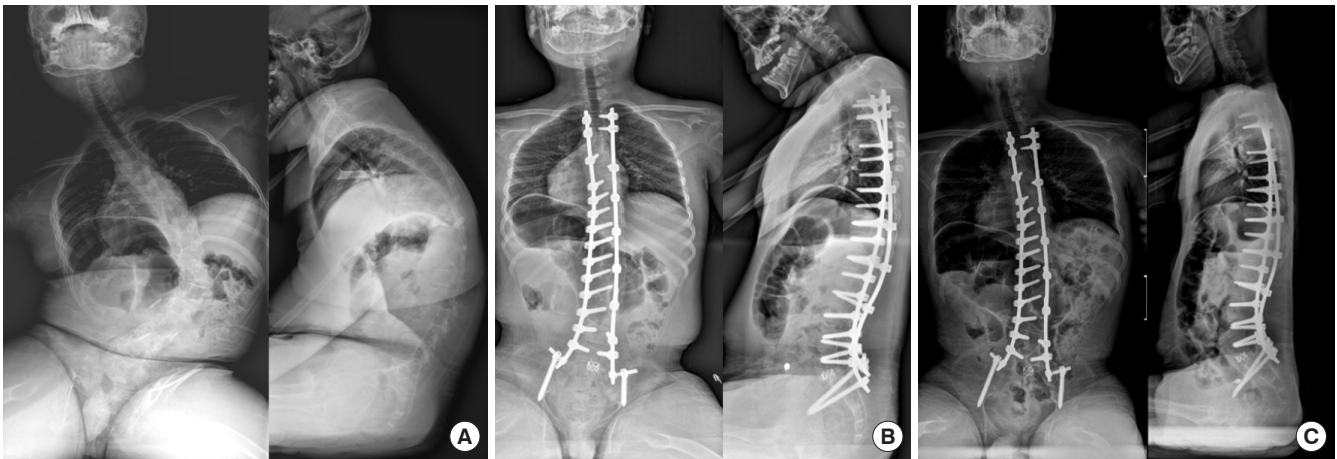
(A) A 15-year-old girl with muscular dystrophy had 56° (T6–T12) of neuromuscular scoliosis in the posteroanterior whole spine radiography in the sitting position. (B) She underwent L5/S1 oblique lateral interbody fusion and posterior instrumentation from T1 to the pelvis. (C) Pelvic obliquity was successfully corrected and maintained until the postoperative 6-year follow-up.
